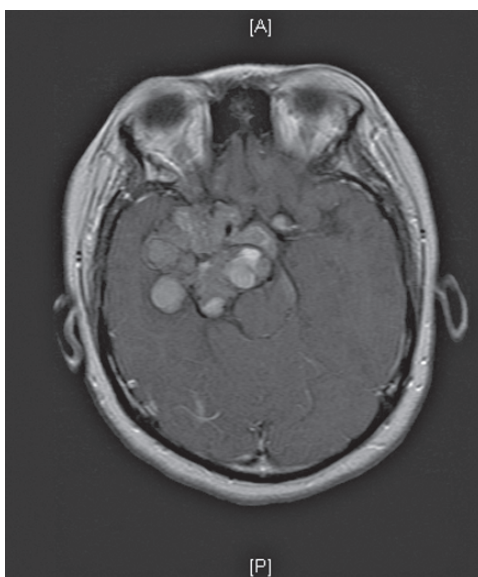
Magnetic resonance imaging (MRI) shows a large, $7.6 \times 5.6 \times 7.9$ cm (craniocaudal and anteroposterior by transverse) macrolobulated heterogeneous but predominantly T1 and T2 isointense enhancing mass
